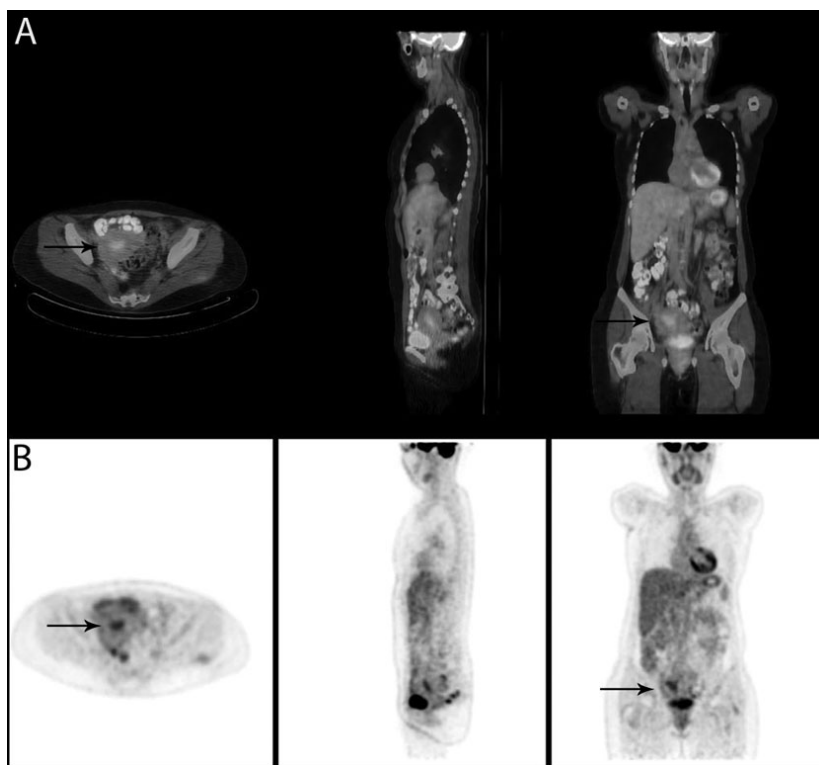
Transaxial, sagittal and coronal PET/CT fusion images (A), and transaxial, sagittal and coronal PET images (B) showing mildly increased F-18 FDG uptake in uterine cavity (SUVmax: 3.5, SUVmean: 3.2)(arrows). No any other pathological PET findings were present in the whole body scan.
